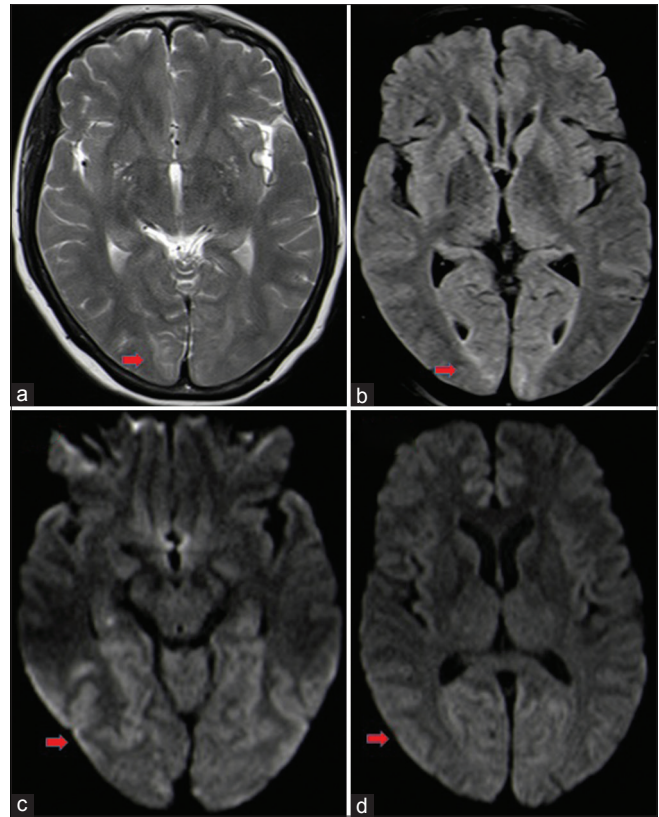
Magnetic resonance imaging brain showing T2 and fluid-attenuated inversion recovery hyperintensities (a and b) in bilateral occipital subcortical white matter, suggestive of posterior reversible encephalopathy syndrome. Diffusion image showing cortical hyperintensities (c and d) in occipital, parietal, and temporal regions (likely postictal changes)
